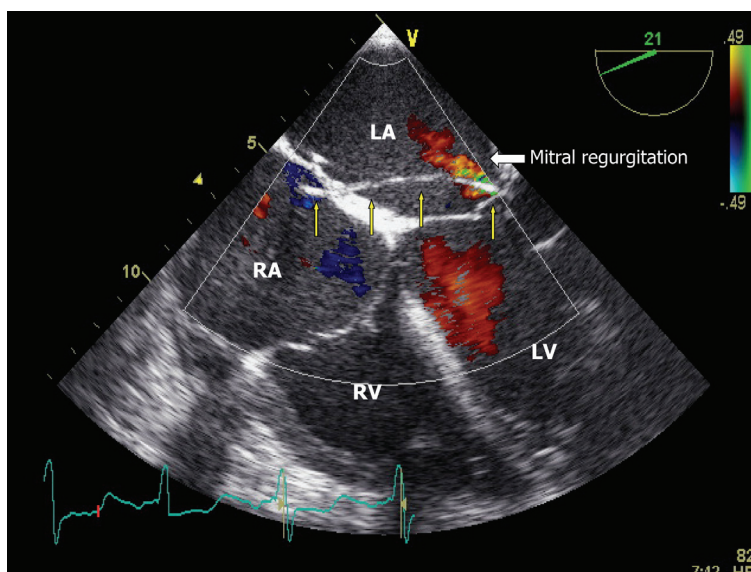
Trans esophageal echocardiogram showing the position of the LV pacing lead crossing the atrial septum and mitral valve (arrows). There is a low grade mitral regurgitation at the site of the pacing lead.
